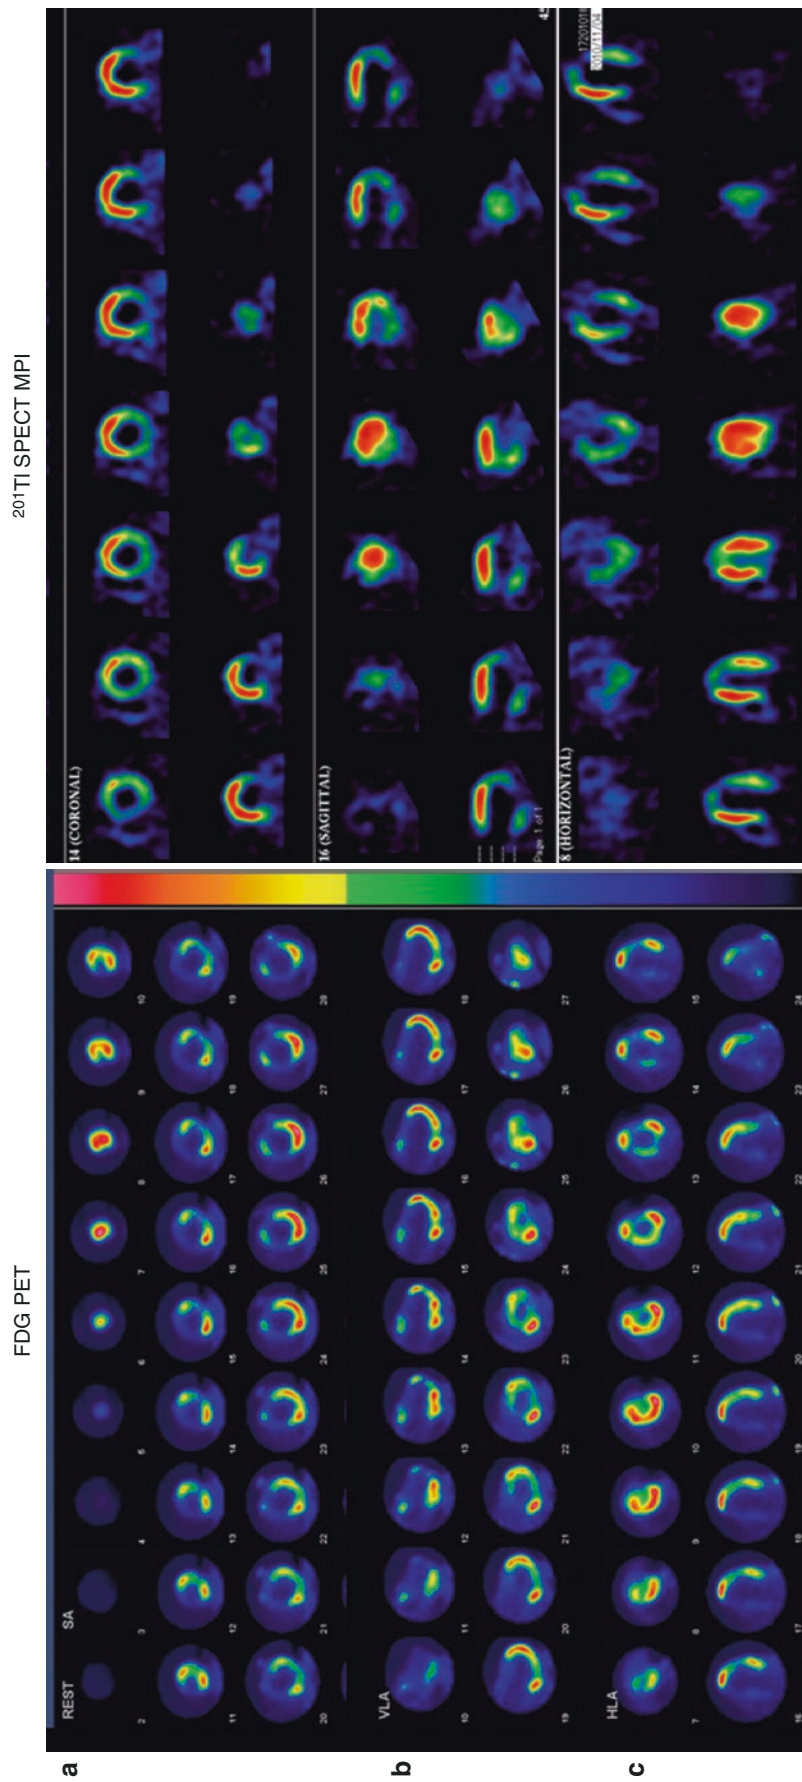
The left is myocardial FDG PET and the right is resting thallium-201 (²⁰¹Tl) SPECT MPI. a: LV short-axis, b: vertical long-axis, and c: horizontal long-axis images. The myocardial FDG PET has a focal on diffuse pattern. In addition, a mismatch pattern between perfusion defect on ²⁰¹Tl SPECT MPI and FDG uptake on PET is also observed. Resting perfusion defects can either be due to compression of the microvasculature by inflammation or be due to scarring [19]
